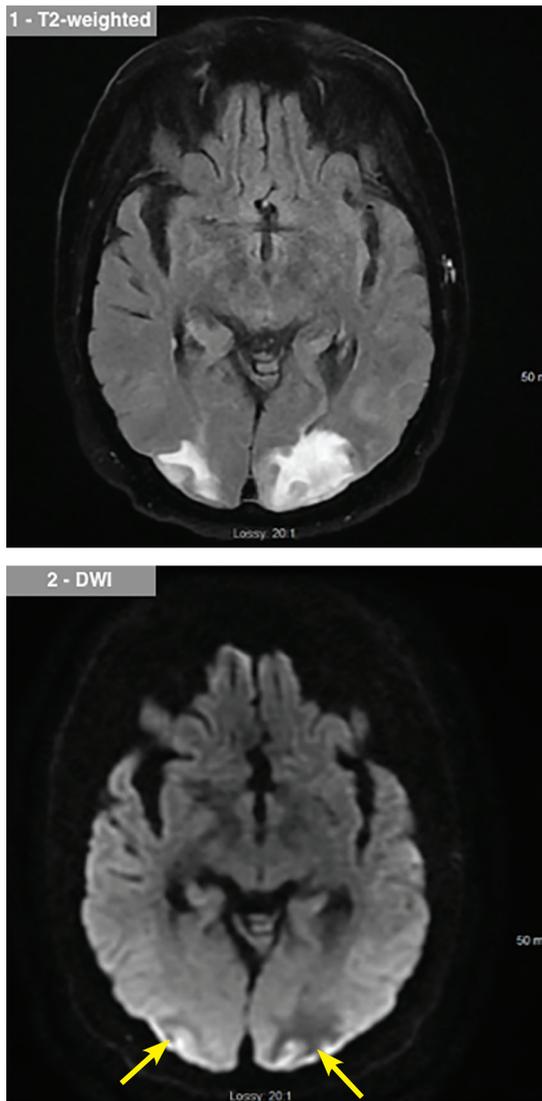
Magnetic resonance imaging on hospital day 4 noted hyperintensities on T2 (top) and diffusion-weighted images (bottom), confirming findings on tomography.
